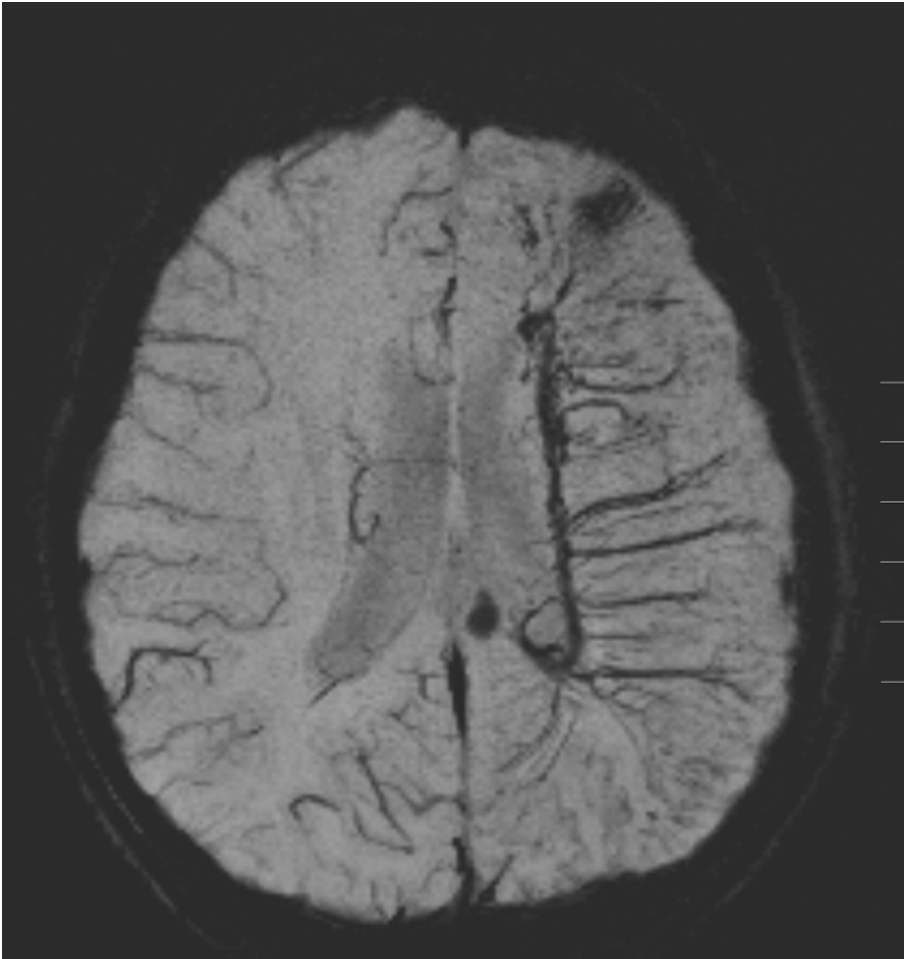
MRI brain showing a large DVA, draining the entire left cerebral hemisphere (patient from Groote Schuur Hospital).
